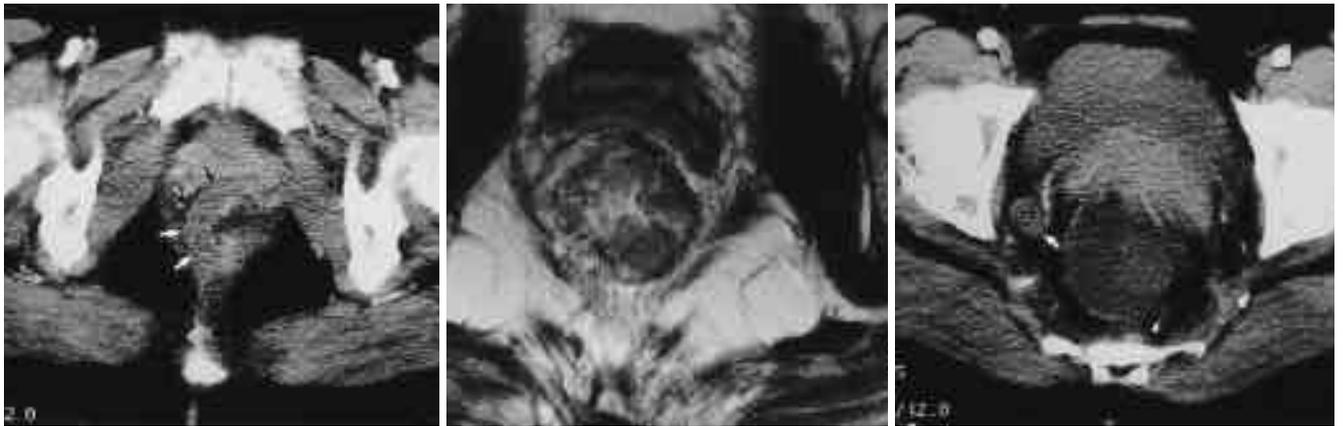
A 41-year-old woman with rectal carcinoma of pathologic stage T3N2. Arterial phase spiral CT scan (A) shows marked thickening of right side of the rectal wall (arrows), but no definite extension of tumor beyond bowel wall can be seen. However, TSE T2-weighted axial image (B) shows definite perirectal infiltration at right posterior aspect (asterisk). CT scan (C) above A shows enlarged right internal iliac lymph node (arrow) and perirectal lymph node (arrowhead), which corresponds to N1. However, TSE T1-weighted coronal (D) and axial (E) images show two enlarged right internal iliac lymph nodes (i) and three perirectal lymph nodes (arrows). Three another perirectal lymph nodes were noted on additional images (not shown). CT was underestimated as T2N1, but MRI stage was correct as T3N2.
